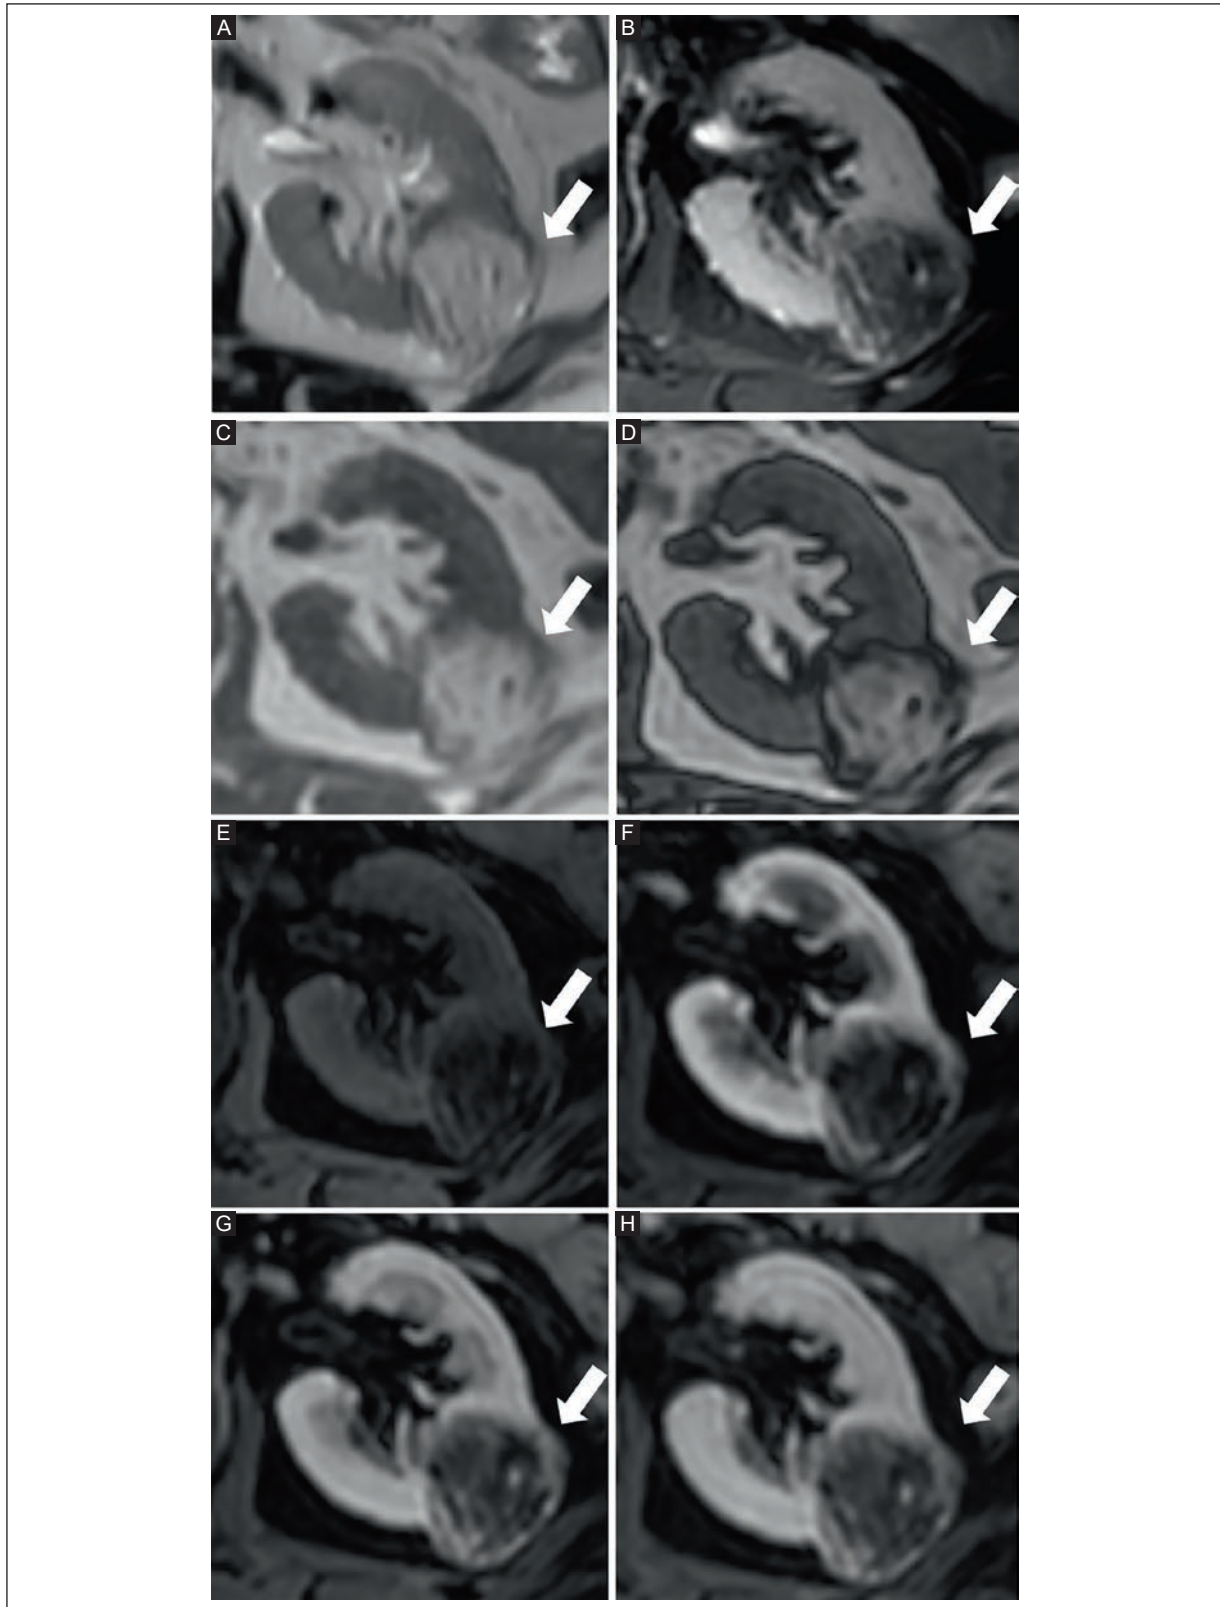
MRI of a 71-year-old woman with a left renal AML A: a typical appearance, characterized by a signal similar to fat, hyperintense on T2-WI (arrow). B: signal drop on T2 fat-saturated sequence (arrow). C: hyperintense on T1-WI (arrow). D: no signal drop on T1 opposed-phase image (arrow). E: hypointense on T1 fat-saturated non-contrast sequence (arrow). F: arterial phase, G: venous phase, and H: late phase T1 post-contrast images show heterogeneous enhancement, corresponding to the vascular component (arrows).
